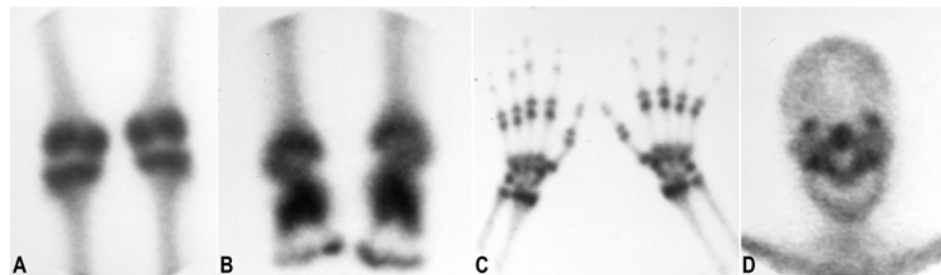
^{99m}Tc bone scintigraphy shows symmetric and abnormally increased technetium uptake in (A) the distal ends of the femurs and the proximal ends of the tibiae, (B) the distal ends of the tibiae and the tarsal bones bilaterally, (C) the distal ends of the ulnae and the radii as well as bilaterally in some of the carpal bones, the proximal and distal ends of the metacarpal bones and the proximal ends of the proximal phalanges, and in (D) the facial bones.
